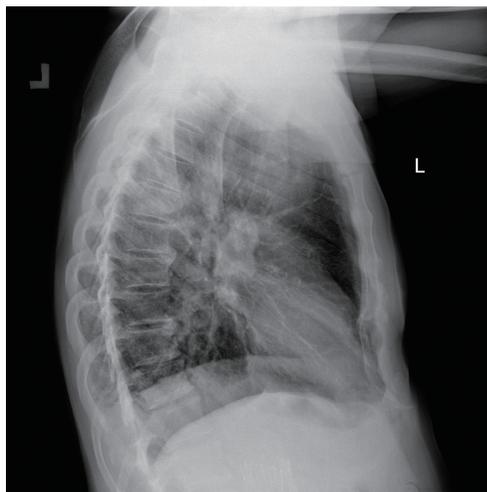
Chest X-ray, latero-lateral view. Oval lesions in area Th4/Th5
